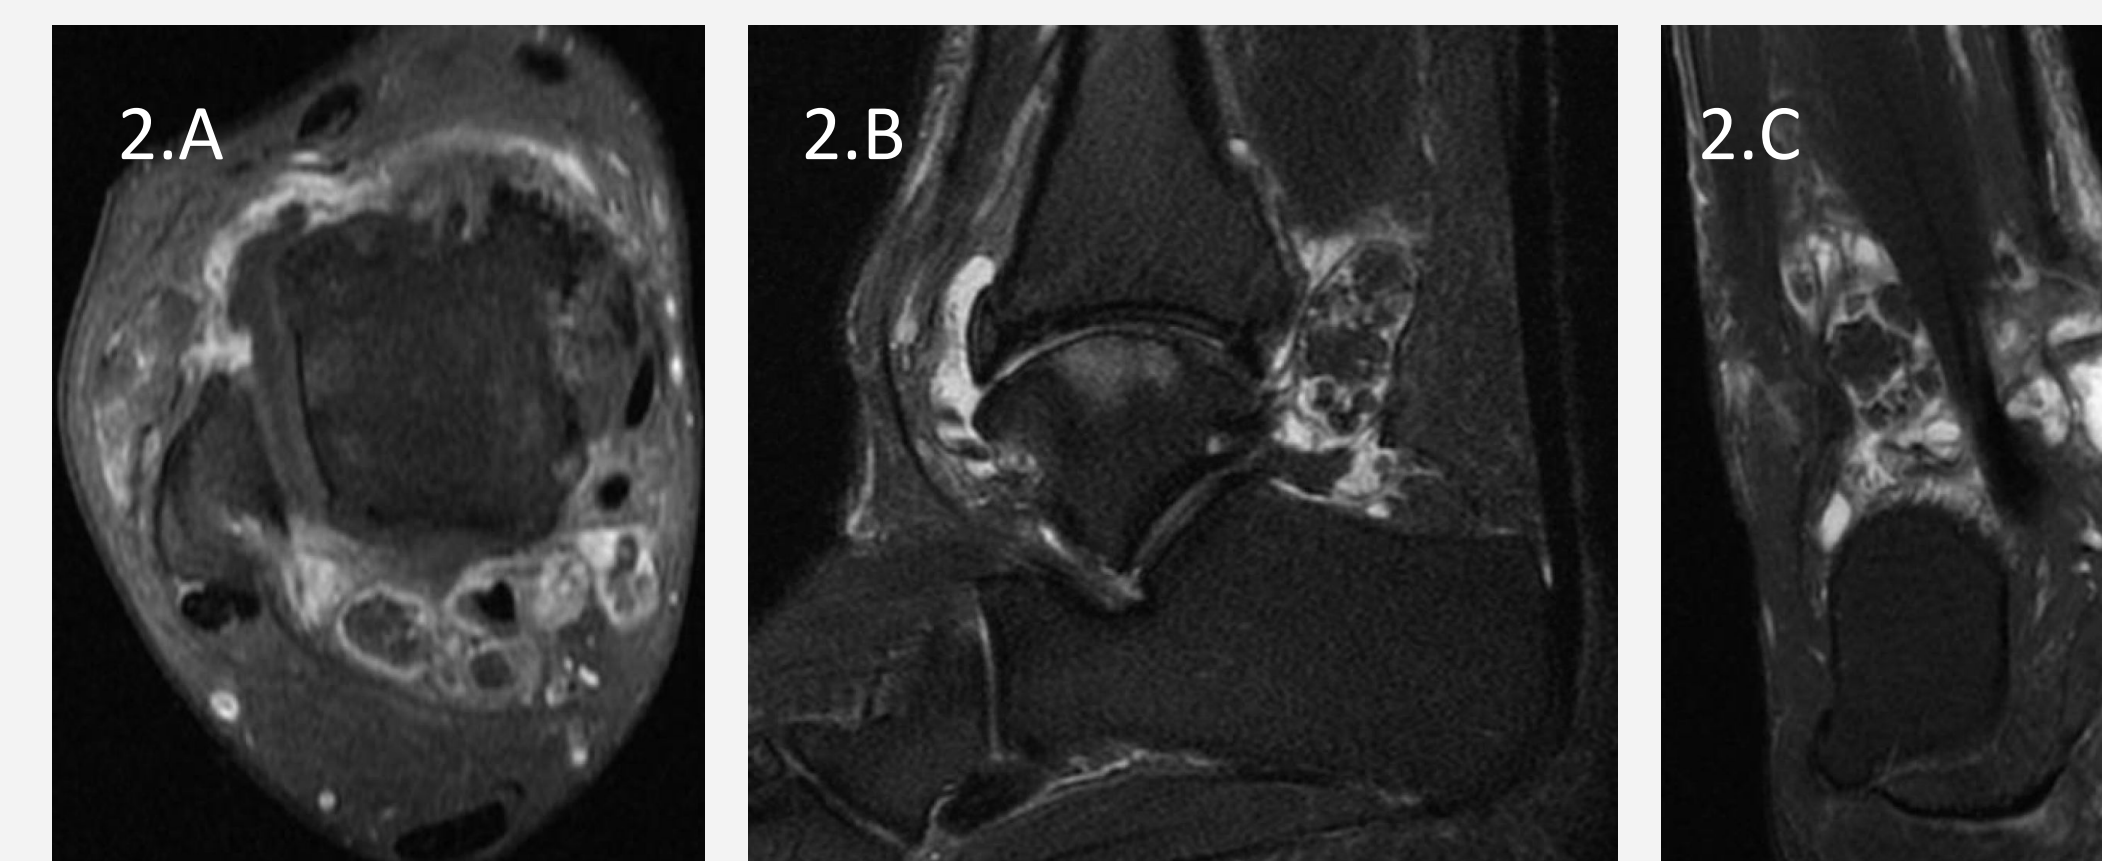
A: Transverse T2 weighted MRI image with extensive peri ankle joint involvement. (Case #2)
